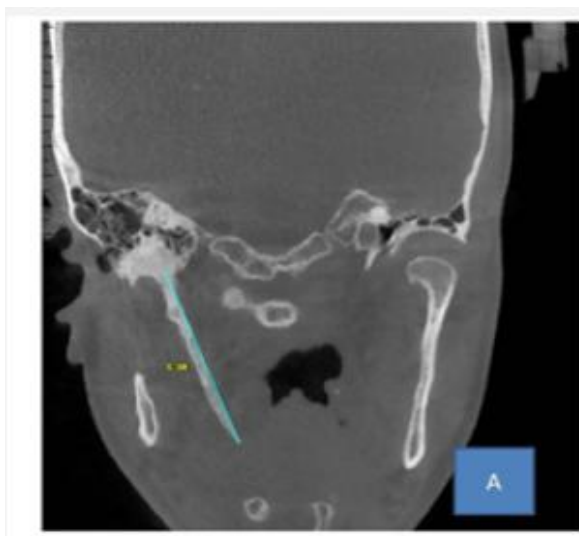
A CT scan of the neck is done to measure the length of the styloid process. This image shows elongation of the right styloid process
